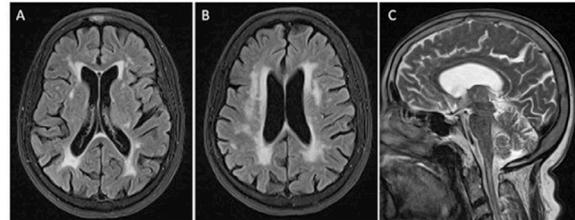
Brain MRI. Axial T2 FLAIR sequences showing severe ischemic leukoencephalopathy (A-B); Sagittal T2 sequence displaying mild ponto-bulbar atrophy (C).
